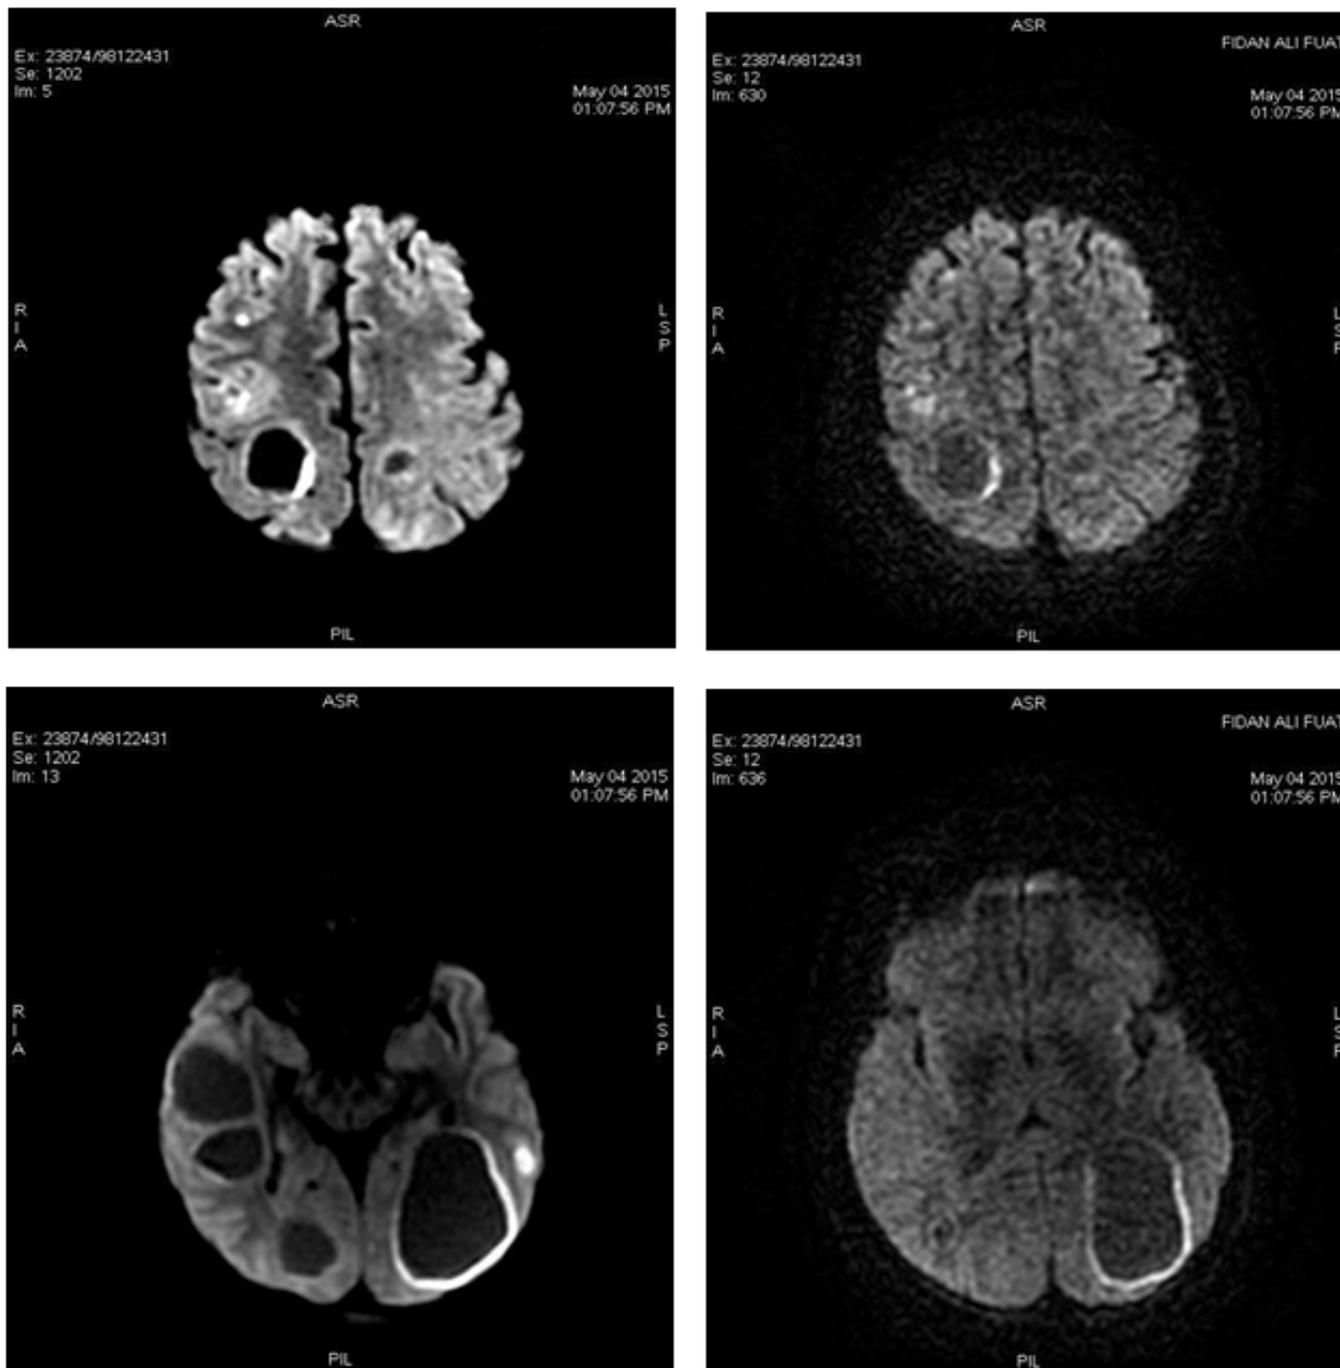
On DWI sequences, lesions demonstrated peripheral restricted diffusion.
